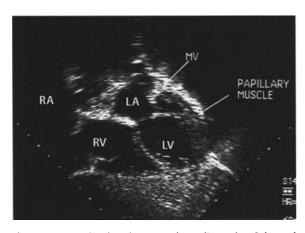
Mitral valve disease: echocardiography. Subcostal 4-chamber view showing a parachute mitral valve (*LA* left atrium, *LV* left ventricle, *MV* mitral valve, *RA* right atrium, *RV* right ventricle) (photograph courtesy of Dr. Nicole Sekarski)
